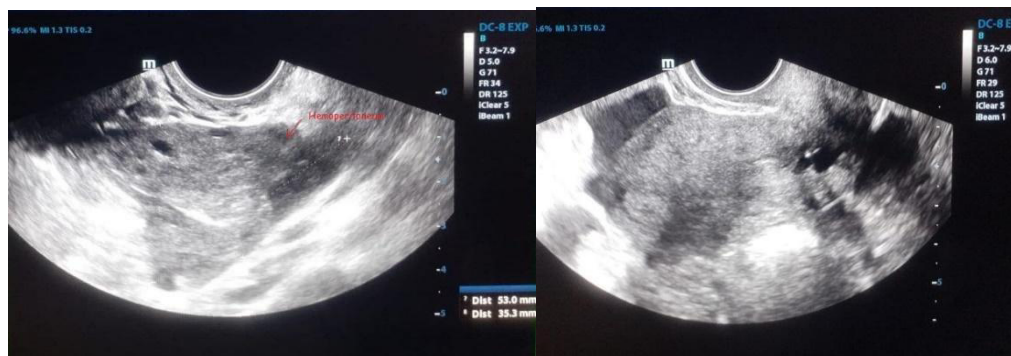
Ultrasonography of abdomen and pelvis showing organized haematoma
